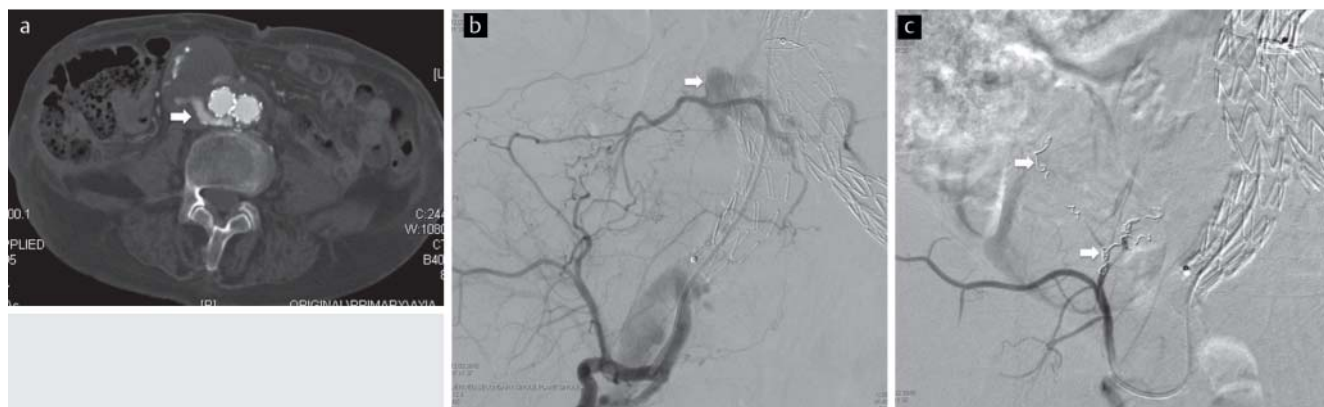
a–c Treatment of type II endoleak. 84 years old male patient with EVAR one week ago. The postinterventional CTA shows a type II endoleak with substantial perfusion of the aneurysm sack a. The selective angiogram of the right internal iliac artery via a brachial access shows a typical type II
